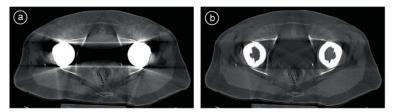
Bilateral metal-on-metal total hip arthroplasties without (a) and with (b) the use of an orthopedic metallic artifact reduction (O-MAR) technique in a CT scan.
